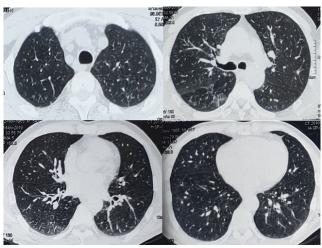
HRCT after 9 month showing complete resolution of lung opacities
